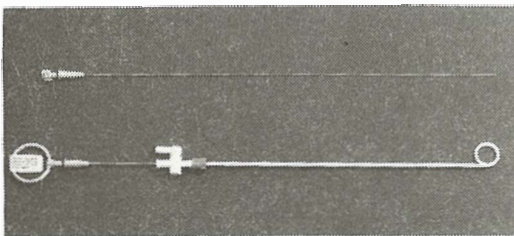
Pigtail drainage tube for application under sonographic guidance
